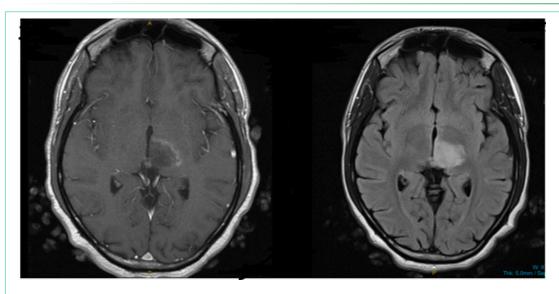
MRI brain axial view T2 FLAIR (left) and T1 with contrast (right) demonstrating hyperintensity with incomplete enhancement along the left thalamus.
